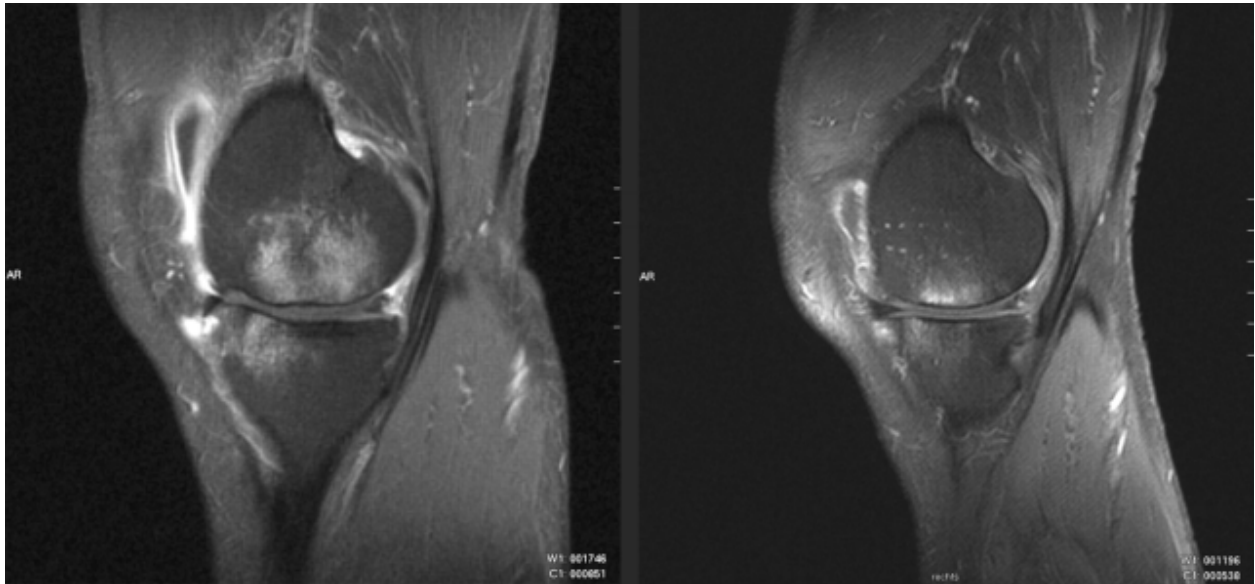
MR images in the sagittal plane of a knee joint with Bone Marrow Lesions (BMLs) in the subchondral compartments of the distal femur and proximal tibia. These are the regions of diffuse white signal within the bone compartment
